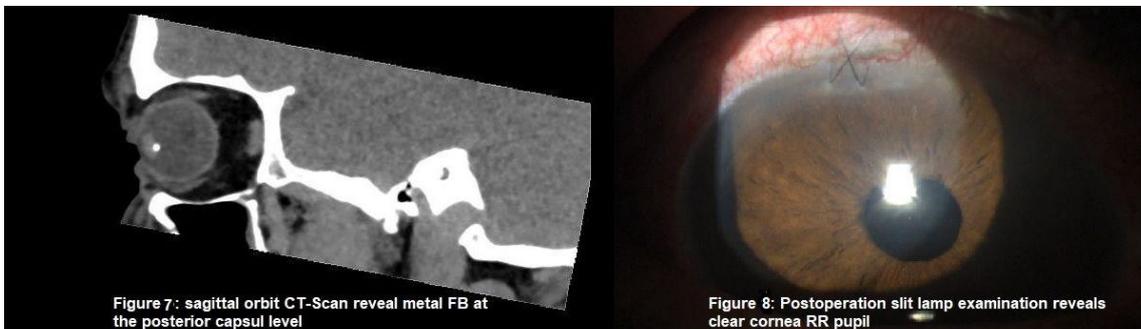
sagittal orbit CT-Scan reveal metal FB at the posterior capsular level
